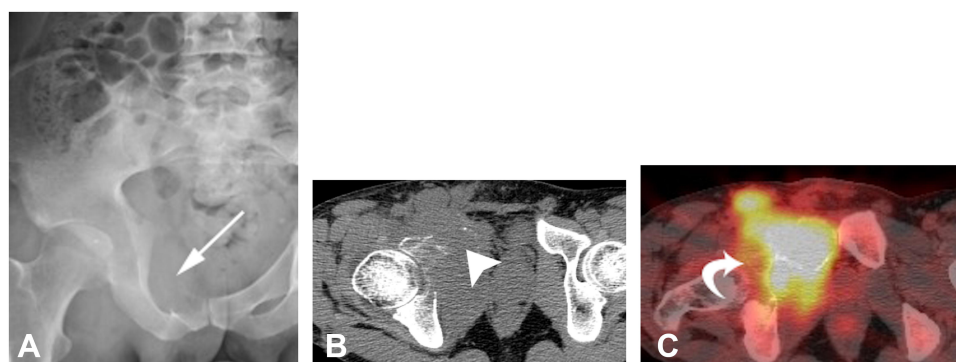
Bone metastases of NSGCT in a patient presenting with seminoma and PET-avid osseous metastasis. (A) Pelvic radiography showing geographic lytic lesion involving right superior pubic ramus. (B and C) Axial CT of pelvis showing geographic mass lesion with soft-tissue component involving superior pubic ramus with corresponding increased FDG avidity.
